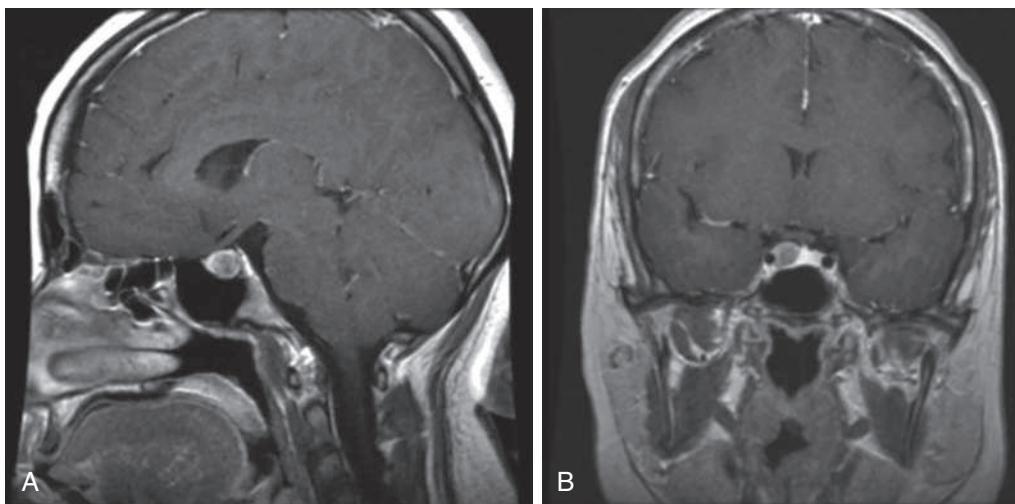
Sagittal (A) and coronal (B) post-gadolinium T1-weighted MRI scans of a female with a microprolactinoma on the right side of the sella, who presented with amenorrhea and galactorrhea. Her serum prolactin was 89 ng/mL. (From Wong A, Eloy JA, Couldwell WT, Liu JK. Update on prolactinomas. Part 1: clinical manifestations and diagnostic challenges. *J Clin Neurosci.* 2015;22:1562–1567, Fig. 1, p. 1563.)
